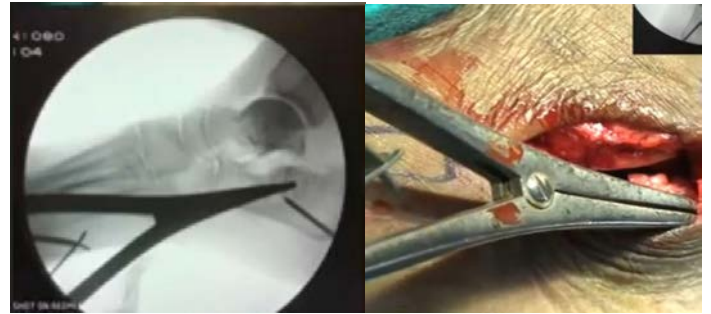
X-Ray picture of use of distractor to achieve height and restore length
